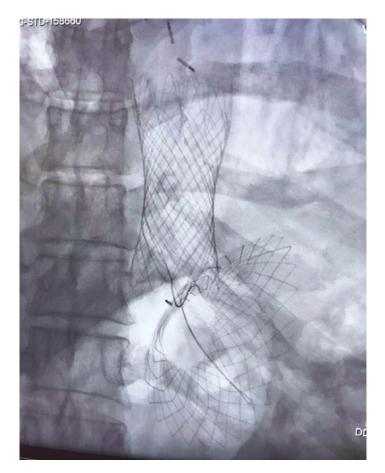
Radiographic aspect of the intragastric satiety-inducing device placed through the esophagogastric junction
